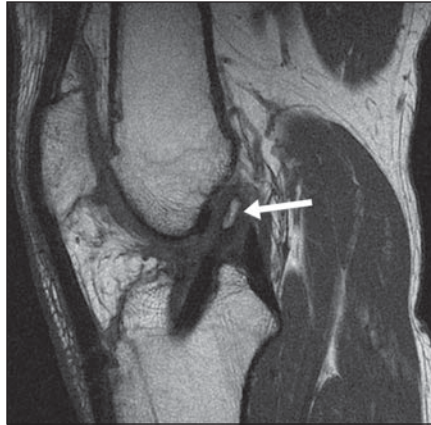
Displaced tibial bone plug in 25-year-old man who presented for follow-up imaging after undergoing anterior cruciate ligament reconstruction with bone–patella tendon–bone graft. A, Coronal T1-weighted MR image shows tibial bone plug (*arrow*) is displaced into intercondylar notch. B, Sagittal T2-weighted fat-suppressed MR image shows that tibial plug (*arrow*) is displaced superiorly out of tibial tunnel.
